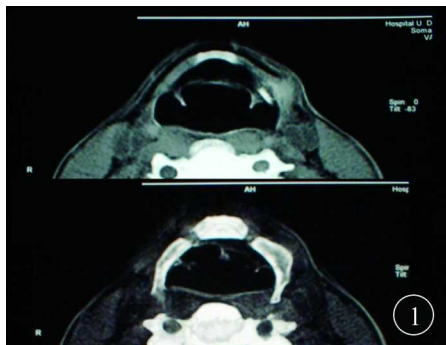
CT in axial cuts. In the superior image it can be observed the chondroma of the superior greater cornu of the left thyroid lamina and in the inferior image the exostosis of the greater cornu of the hyoid bone
